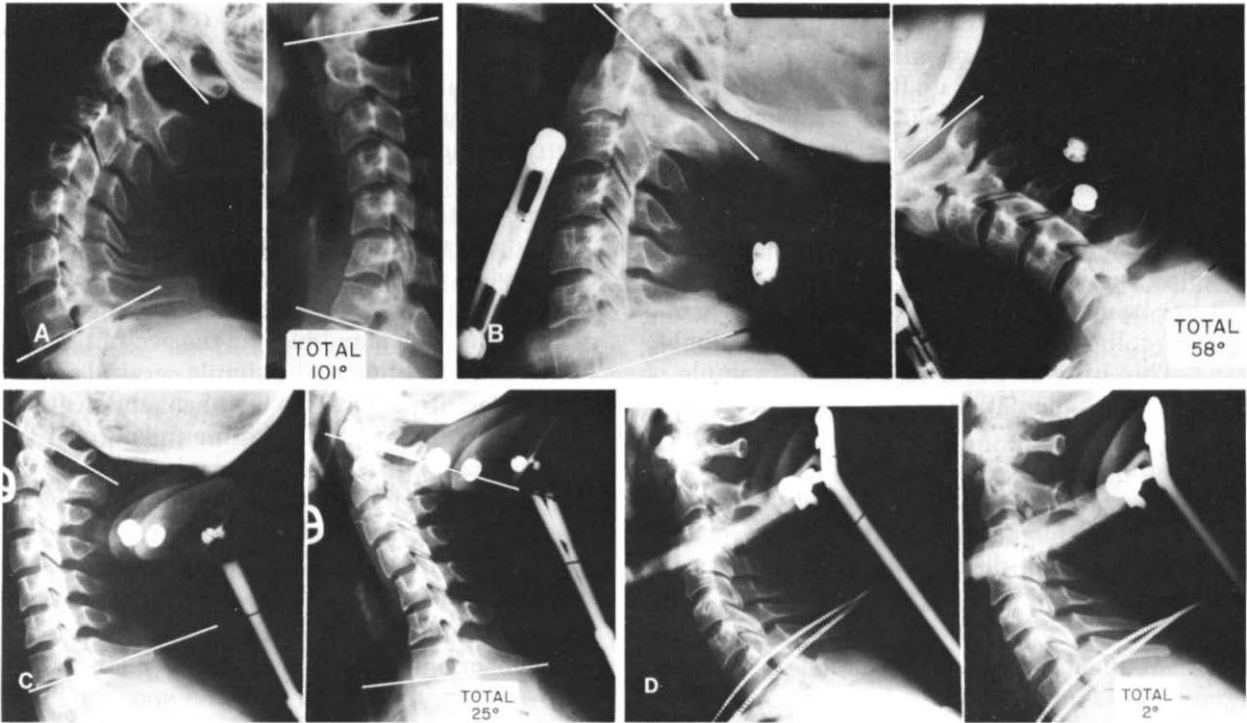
The actual radiographs of the extension/flexion ranges of motion achieved by normal subjects. The range of motion at C1–C7 achieved by these subjects is shown for the different cervical orthoses. (A) Soft cervical collar. (B) Hard plastic collar. (C) Four-poster cervical orthosis. (D) Duke orthosis with occipital chin and chest piece. (Courtesy of R. M. Johnson, M.D.)
